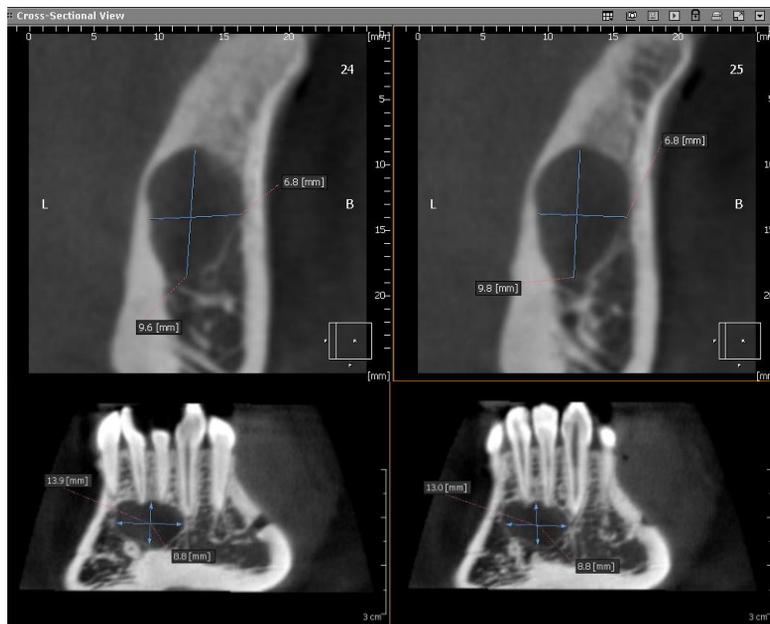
CBCT scan showed the volume of lesion.
